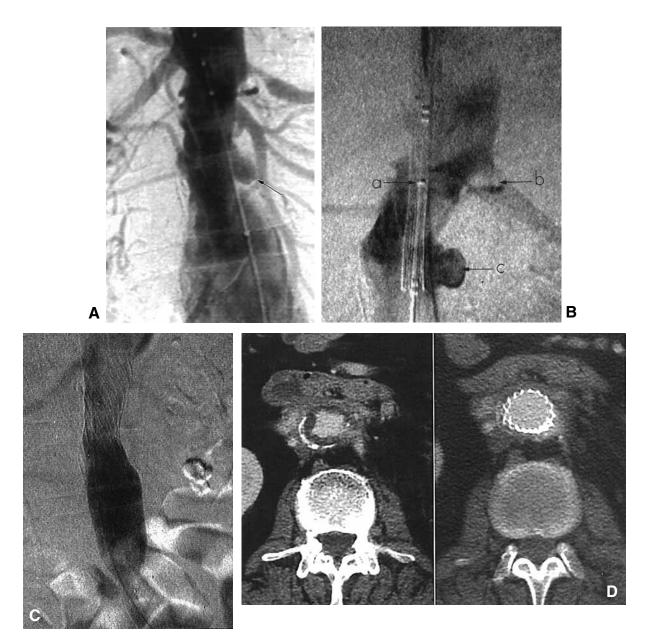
A, Angiogram shows infrarenal aneurysm measuring 6.2 cm. Aortic neck diameter is 2.2 cm (irregular); aortic neck length is 1.5 cm. *Arrow* points to site of penetrating aortic ulcer. B, Intraoperative angiogram in same patient shows optimal positioning and deployment of balloon-expandable endovascular graft. Endovascular stent graft is positioned in such a way that marker on cephalad end of graft (*a*) is at level of left (lowest) renal artery (*b*). This positioning was chosen specifically to exclude previously identified penetrating aortic ulcer (*c*). C, Completion angiogram shows deployment of balloon-expandable endograft. Renal artery perfusion through open portion of stent interstices is apparent. Penetrating aortic ulcer and surrounding aortic neck irregularities have also been successfully excluded. D, CT scans taken before (*left*) and after (*right*) aortic endografting demonstrate mild compression of underlying aortic wall material with rounding of aortic contour.
